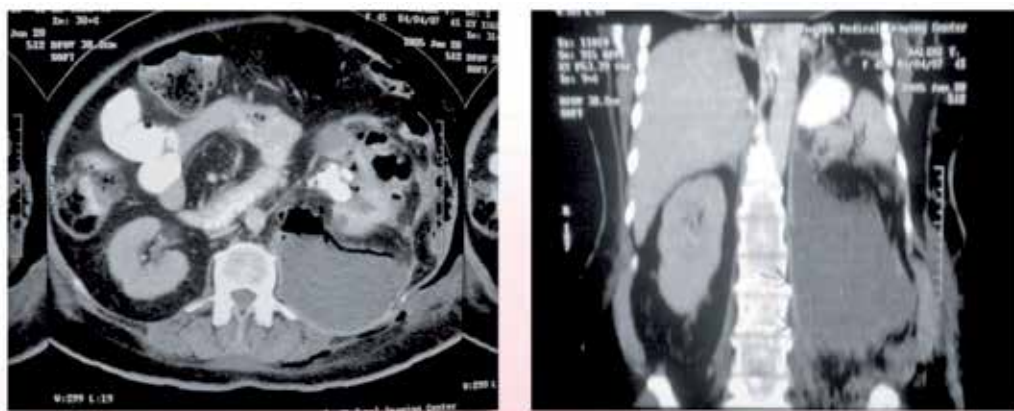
CT scan showing a large collection with air-fluid level in left retroperitoneal cavity.(transverse and coronal view). (Courtesy of Simforoosh N., Sharifiaghdas F., Parvin M.,et al. The book “Urology Cases in Practice”. Labbafinejad Medical Center, Tehran, Iran.)
